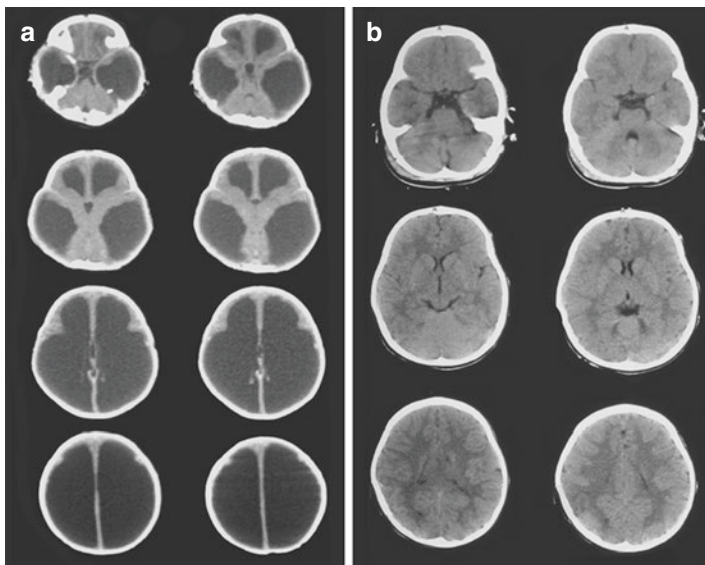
Non-contrast CT scan of an infant with massive hydrocephalus with little cortical mantle (a). Note that in the normal CT scan (b), the third ventricle is slit like and the temporal horns are not easily seen at all and you *can* see the Sylvian fissure easily despite the large cortical mantle compared to (a) where the Sylvian fissure and the sulci are effaced (squashed up)
